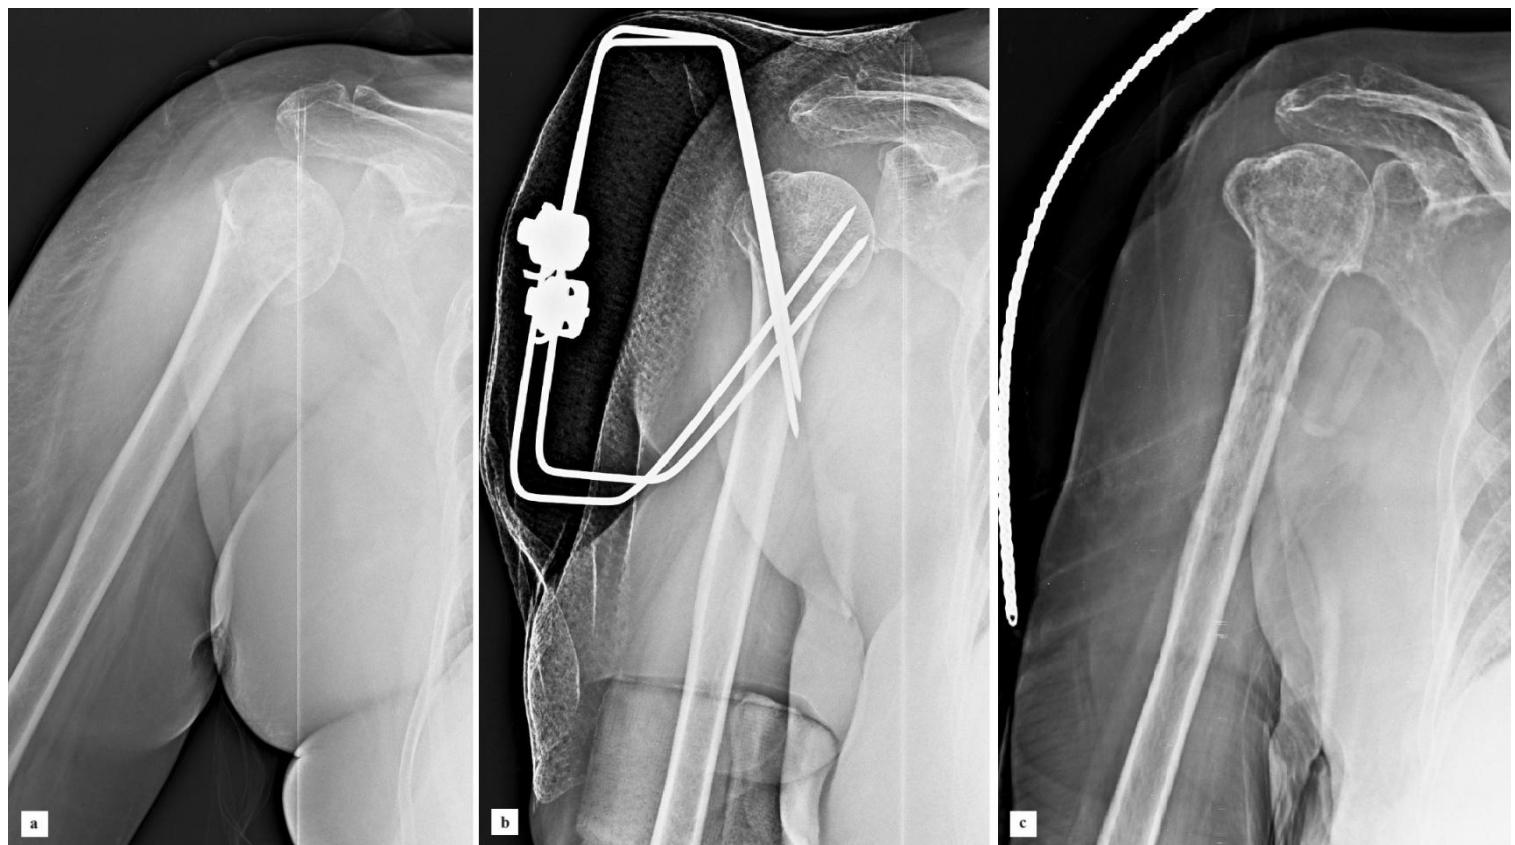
a: Pre-operative X-ray of a three-part displaced proximal humerus fracture; b: Immediate post-operative X-ray after closed reduction and mini-fixator application; c: Follow-up X-ray at 6 weeks, after fixator removal.
